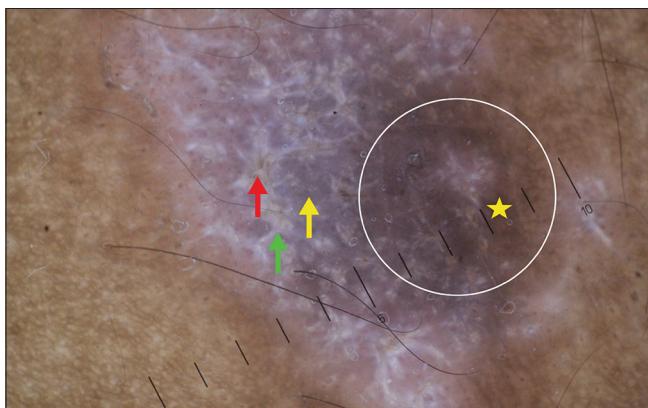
Resolving classical lichen planus: Polarised light dermoscopy after application of ultrasound gel of resolving classical lichen planus. Diffuse brownish pigmentation shows beginning of resolution, whereas; the rest of the area shows sign of activity. The lesion shows reticulate Wickham striae (green arrow), with diffuse brown pigmentation (yellow star), yellow structures (red arrow) and violaceous background (yellow arrow). (original magnification, $\times 10$)
